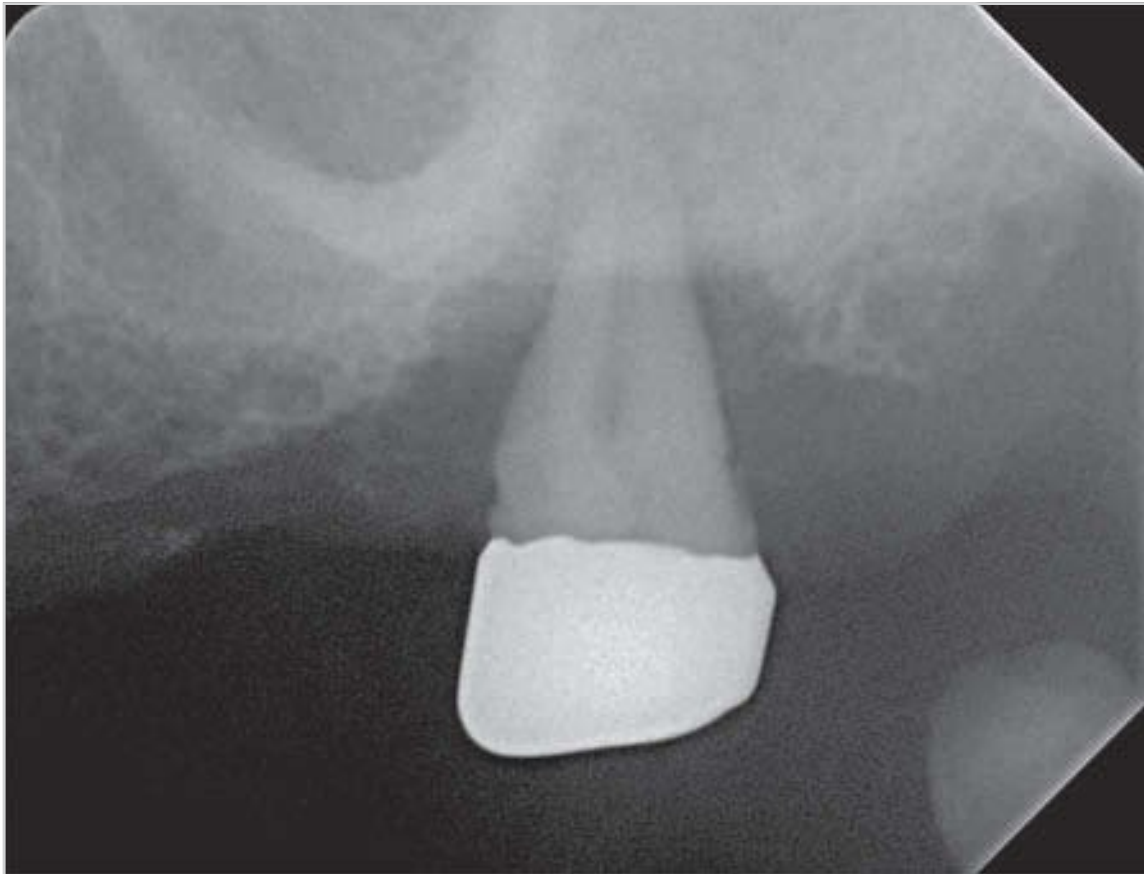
Right-angle technique: radiograph of the maxilla.
